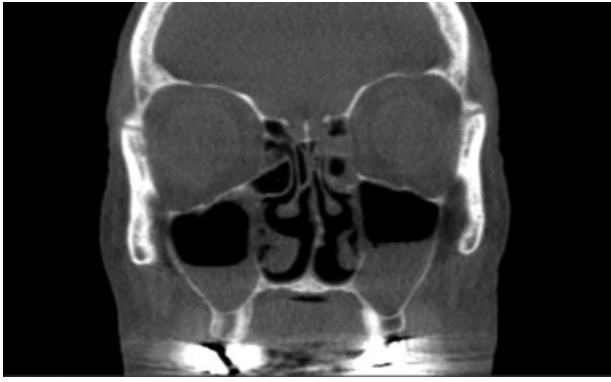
Preoperative sinus CT scan^b frame showing ethmoid sinus mucosal disease and bilateral maxillary sinus air-fluid levels despite multiple medical management regimens over an eight-month period by multiple physicians. This patient underwent an in-office hybrid BSD procedure with bilateral maxillary BSD with partial uncinectomy, bilateral sphenoid and frontal sinus BSD, bilateral anterior and posterior ethmoidectomies, and bilateral outfracture of the inferior turbinates. The inspissated mucous in both maxillary sinuses were removed by suctioning. Recovery was rapid, with the patient playing golf in 48 hours.
